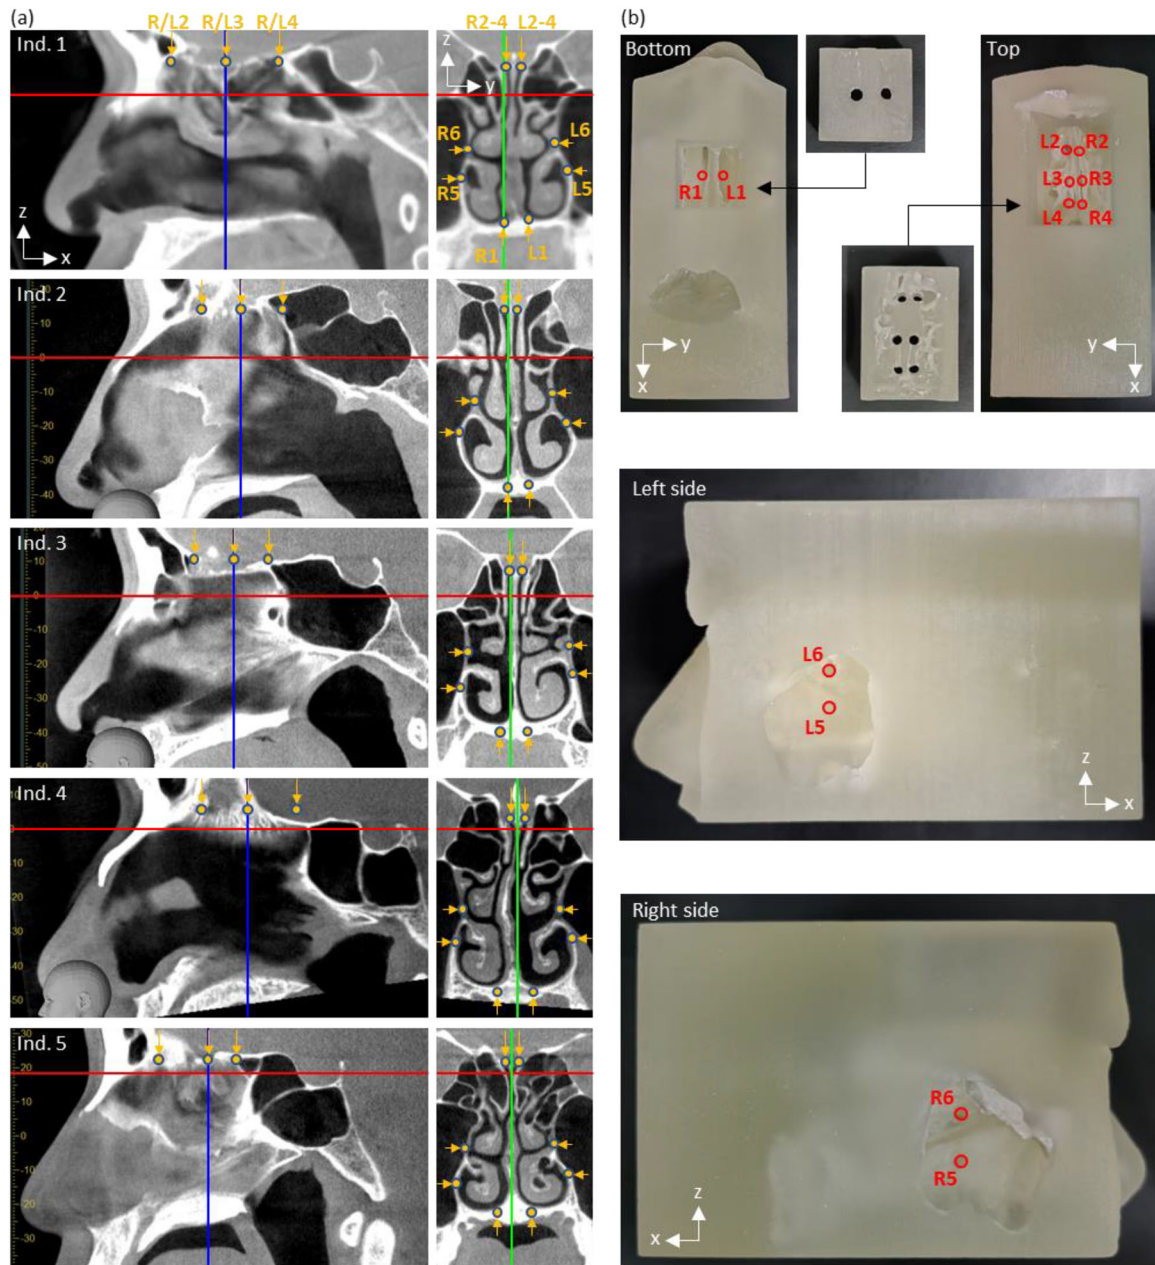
Detailed structure of the 3D-printed nasal cavity model. (a) CT images of five individuals recruited for the present study. For each individual, sagittal and coronal CT images are shown side by side. The blue lines indicate the plane of the coronal section, while the green lines indicate the plane of the sagittal section. The exact positions where through-holes were created for the pressure measurements are indicated by orange dots and arrows in each image. (b) Photographs of the 3D-printed nasal cavity model taken from different directions. The model was fabricated as a three-part assembly: one main body (shown in the “Bottom” and “Top” views) and two detachable small parts (shown in the two smaller photographs between the “Bottom” and “Top” views). The small images of the two parts were included to show the internal contact surfaces that interface with the main body. The labels “Bottom” and “Top” denote the inferior and superior views of the main body, respectively. The positions for inserting a sensor for the pressure differential measurements are marked with red circles and labeled as L1–L6 for the left nasal cavity and R1–R6 for the right nasal cavity. Specifically, points 1 correspond to the nasal floor, 2–4 to the olfactory cleft, 5 to the inferior meatus, and 6 to the middle meatus.
